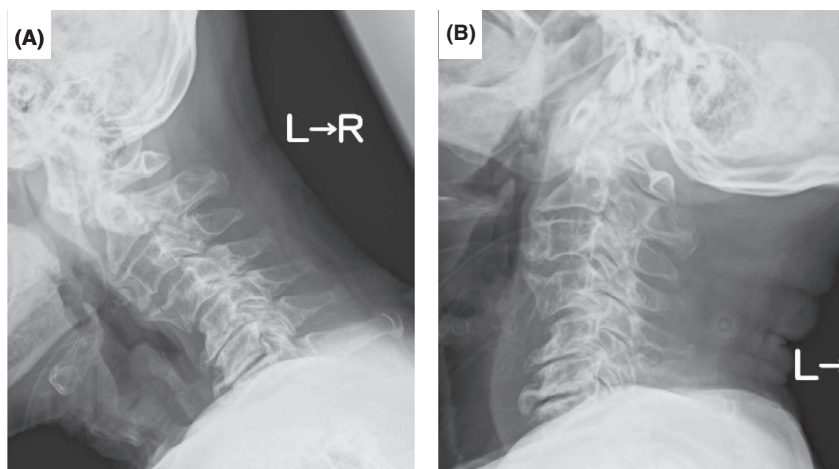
Flexion extension X-rays of the cervical spine on day 3 of hospitalization of an 86-year-old man with retro-odontoid pseudotumor. A, Flexion test revealed no cervical instability. B, Extension test revealed no cervical instability.
